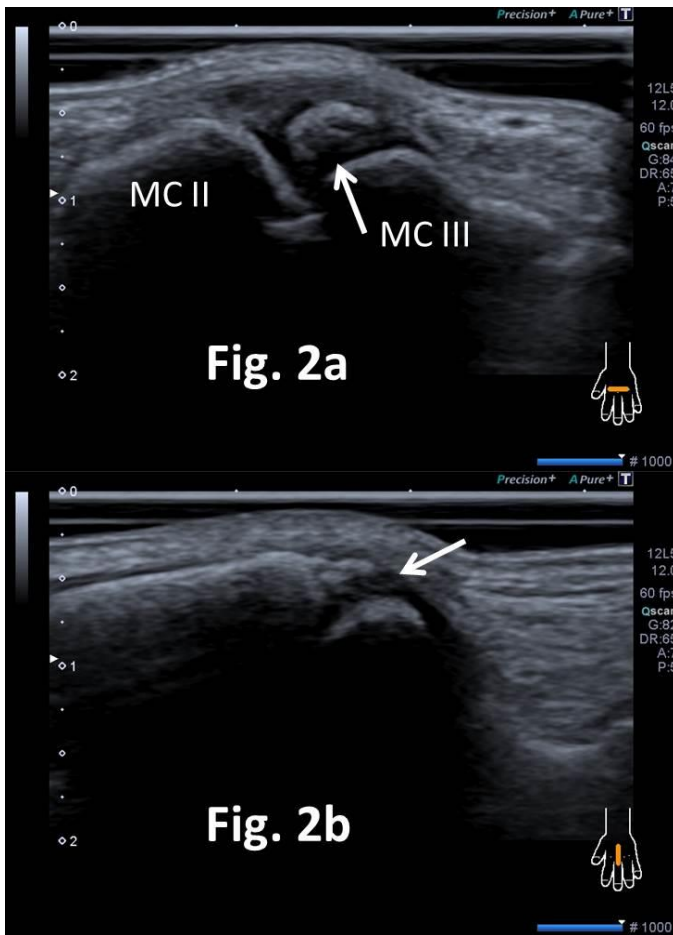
15-year-old male patient with symptomatic os styloideum (Ultrasound of the left hand)
